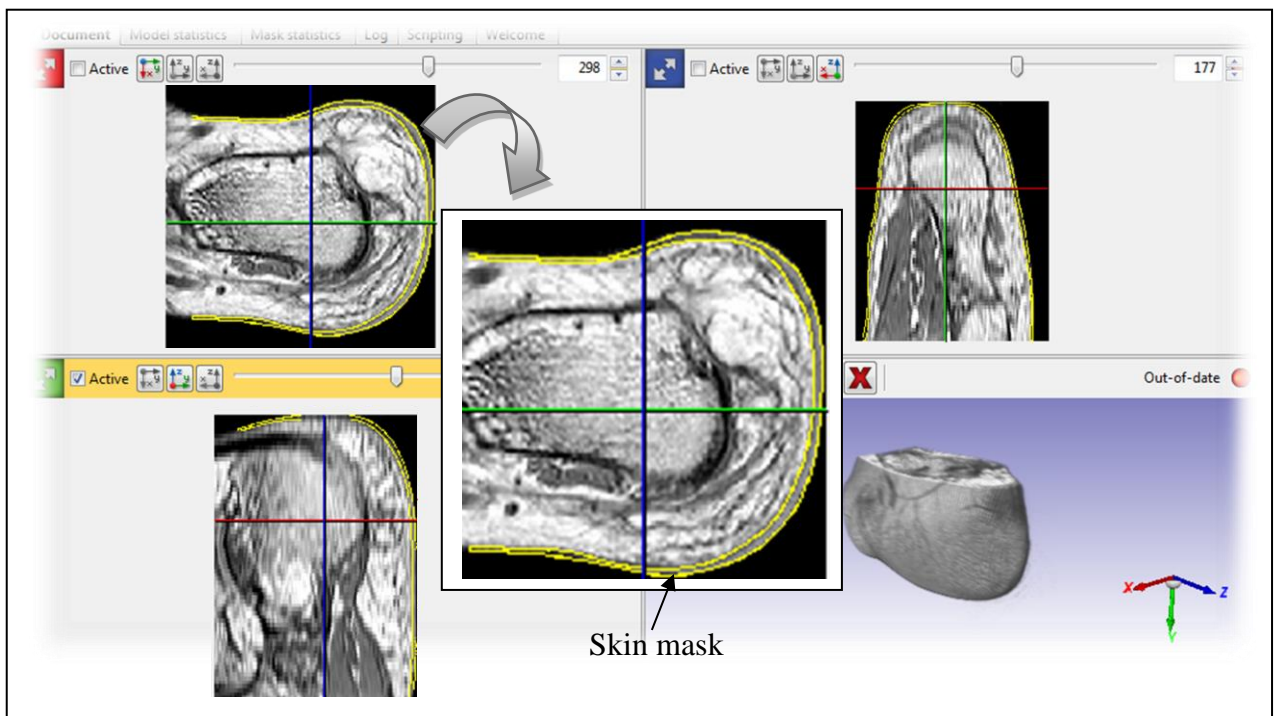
Superimposing the skin mask on to the MRI data. The laying of the mask over the MR images can be seen in coronal, sagittal and transverse views.
